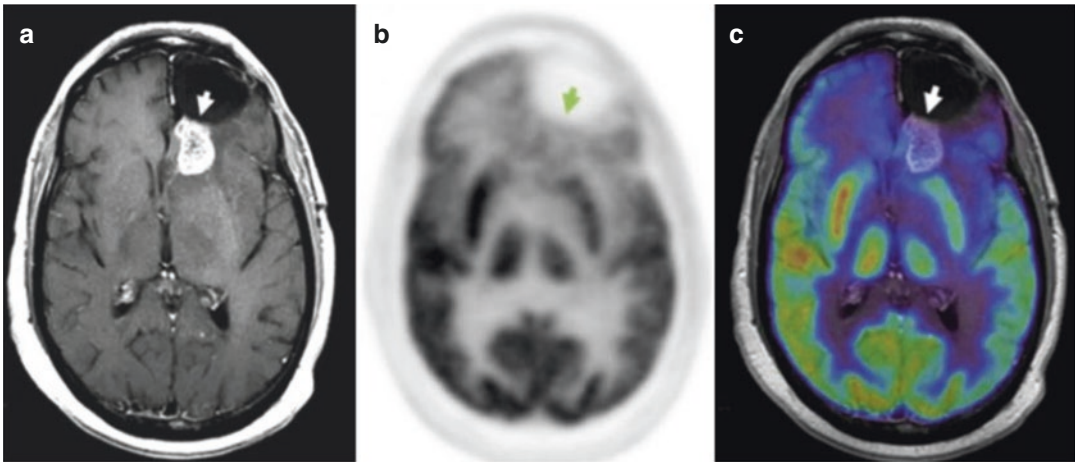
^{18}F -FDG PET diagnosis of pseudoprogression. Patient with a history of glioblastoma, status post resection, and after treatment with total dose of 60 Gy in 2-Gy fractions presents for a follow-up, 1 month after radiation therapy. MRI (a) demonstrates enhancement posterior to the prior resection cavity in the left frontal lobe (arrowhead). However, the patient showed clinical improvement, and therefore an ^{18}F -FDG PET scan was done to assess for tumor progression. On PET (b), no
